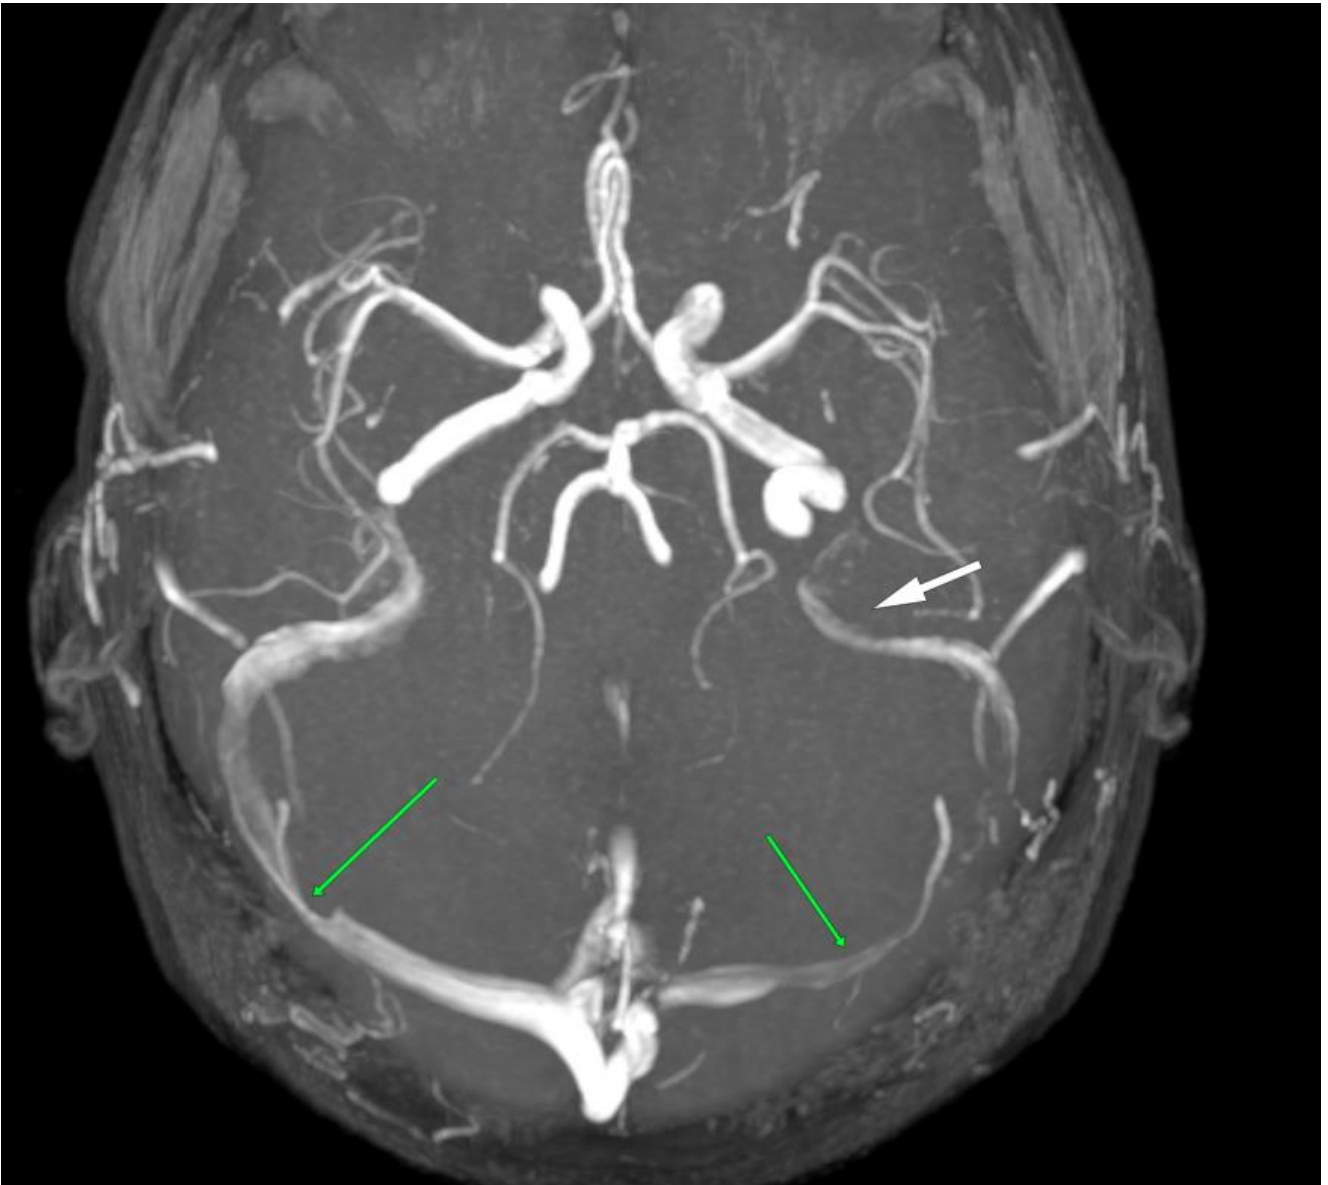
The MR venography does demonstrate stenosis of both the hypoplastic (left) and dominant (right) transverse sinuses. It is possible that this, in tandem with the jugular vein problem, can cause problems. A doppler volume flow exam of the jugular veins can be helpful in proving whether or not there is normal outflow volumes. Flow outflow rate should be no less than 250mL/min per vein, and no less than 700mL combined (5,9).
